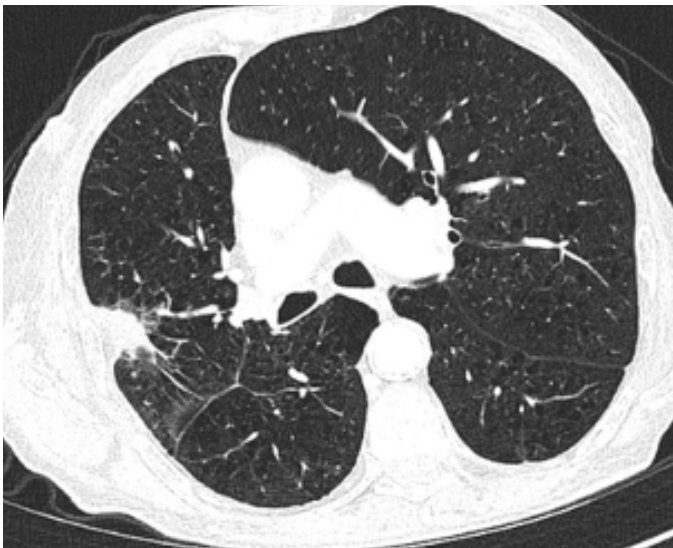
Thoracic CT 3 months after treatment initiation: favourable response of the right upper lobe lesion.
